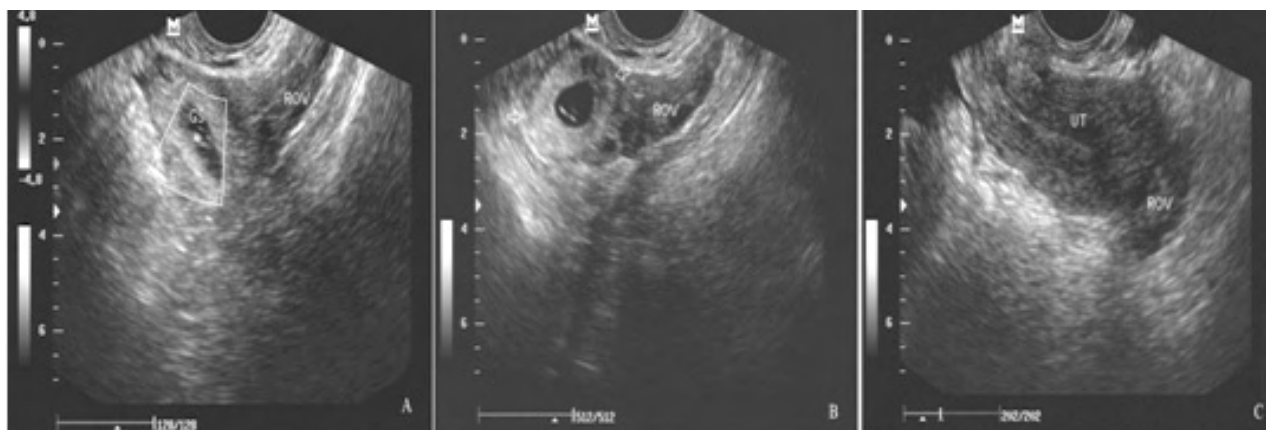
Ultrasound examinations were carried out before UAIE and after UAIE at seven, and 21 days.
